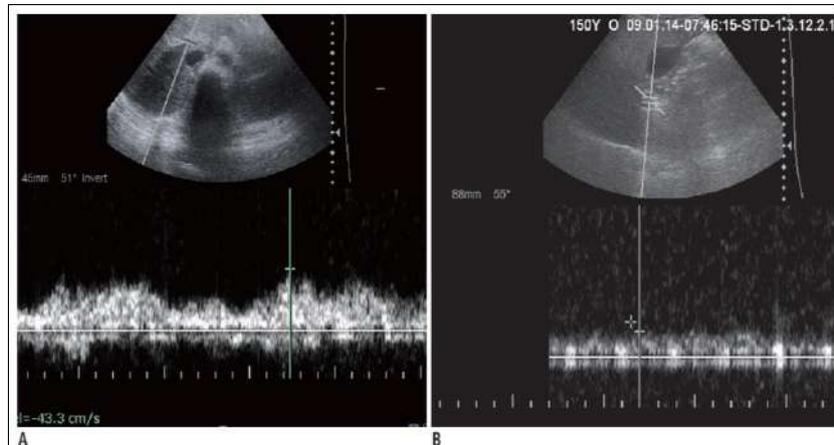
Spectral Doppler US of maximum velocities in portal veins of control subjects and patients with nonalcoholic steatohepatitis (NAFLD). A. Maximum velocity (V_{max} in portal vein of normal subject (43.30 cm/s). B. V_{max} in portal veins of patients with NAFLD (18.10 cm/s).
